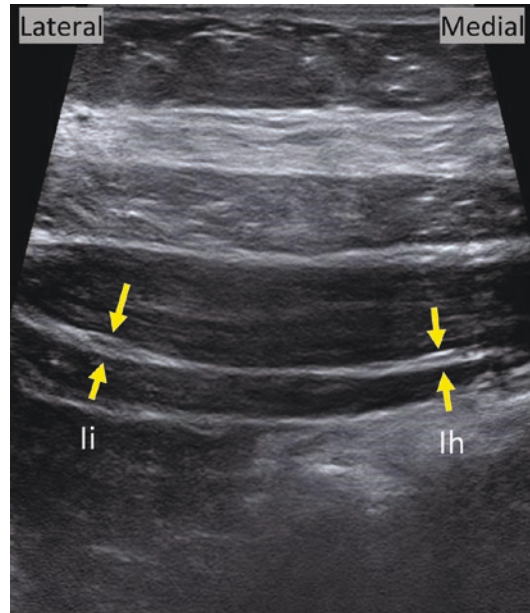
Transverse image (short axis) of normal-appearing ilioinguinal (arrows, li) and iliohypogastric (arrows, lh) nerves using a 9 MHz ultrasound probe. When normal, at times, these nerves can be difficult to identify, but anatomically located between the internal oblique and transversus abdominus muscles. Doppler imaging can be used to differentiate the nerves from adjacent vessels
